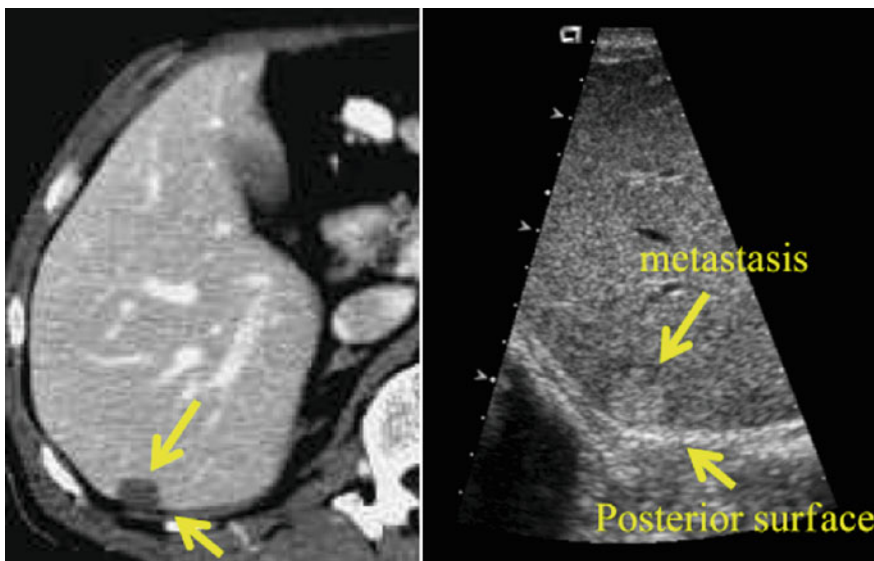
(left) CT with metastasis and posterior edge of liver, and (right) corresponding objects in ultrasound
